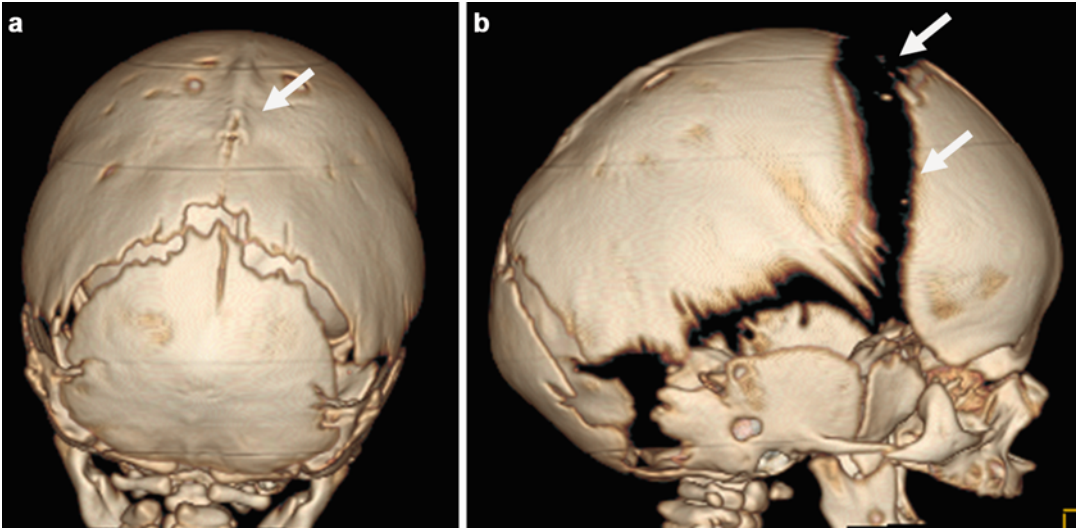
(a, b) A 7-day-old boy was evaluated for Crouzon syndrome. CT scan showed complete sagittal synostosis (*arrow*) with consequent scaphocephaly (a). Partial fusion of the inferior aspect of the metopic suture was noted. The remainder of the sutures (*arrows*) is widened (b) (Courtesy of Dr. Grace Guo)
